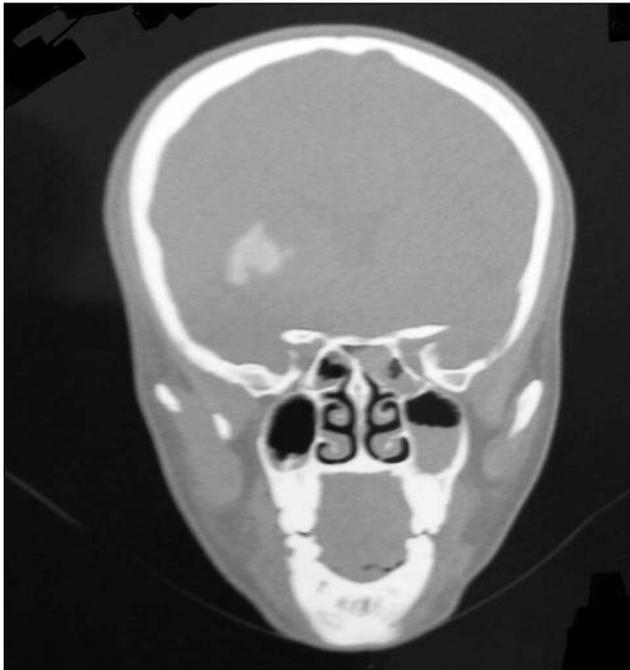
Skull MRI (May 2015)
